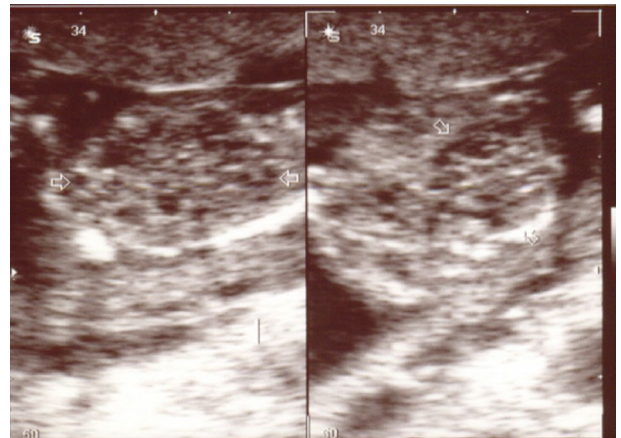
Ultrasonography view of both fetuses' occipital encephalocele
